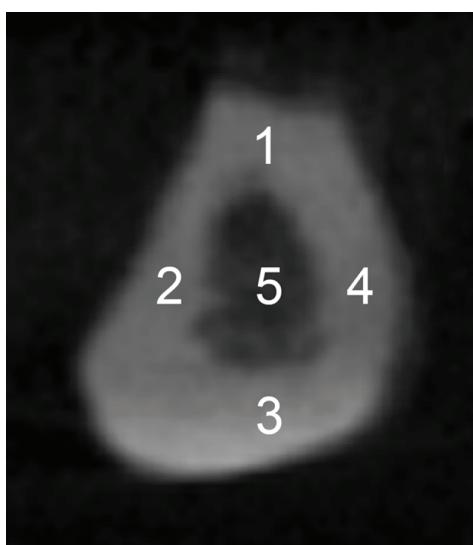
Cone beam computed tomography images of a fibula showing the five measurement areas of the cortical bone thickness and density (areas 1-4), and the spongy bone density (area 5)
